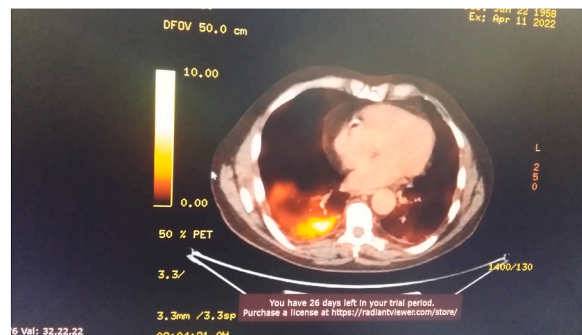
Positron emission tomography with an area of high 16SUV uptake.
